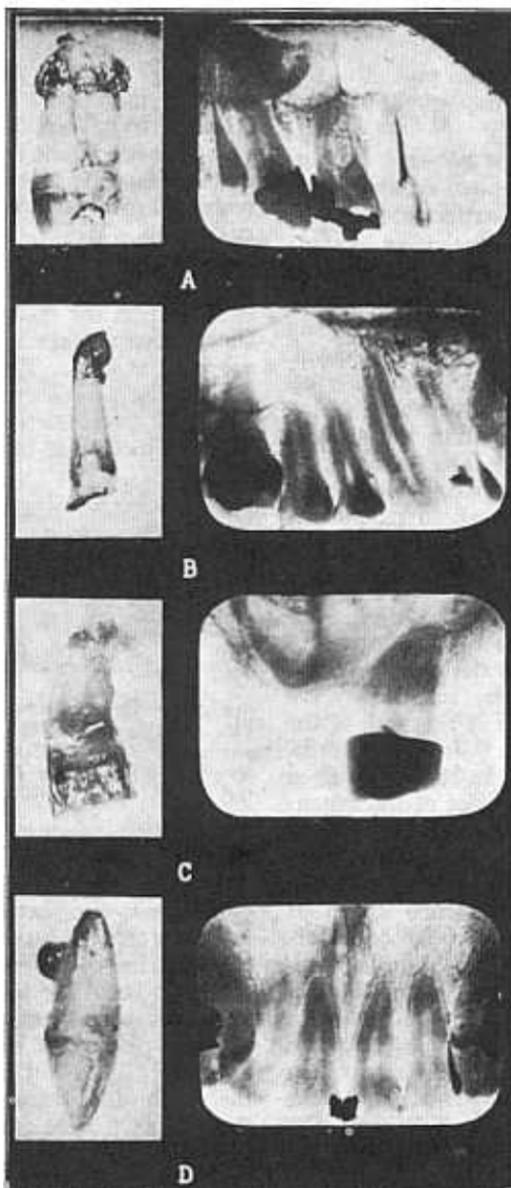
Comparison of roentgenographic appearances with the actual, as revealed by photographs of extracted teeth with granulomas. The absence of roentgenographic evidence of periapical involvement may be noted.
